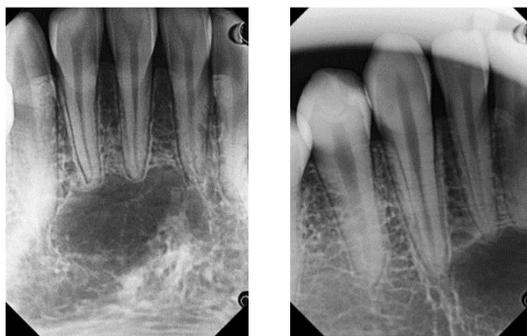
Periapical radiographic image showed a radiolucent lesion from teeth #s 43,42,41 and 31.
